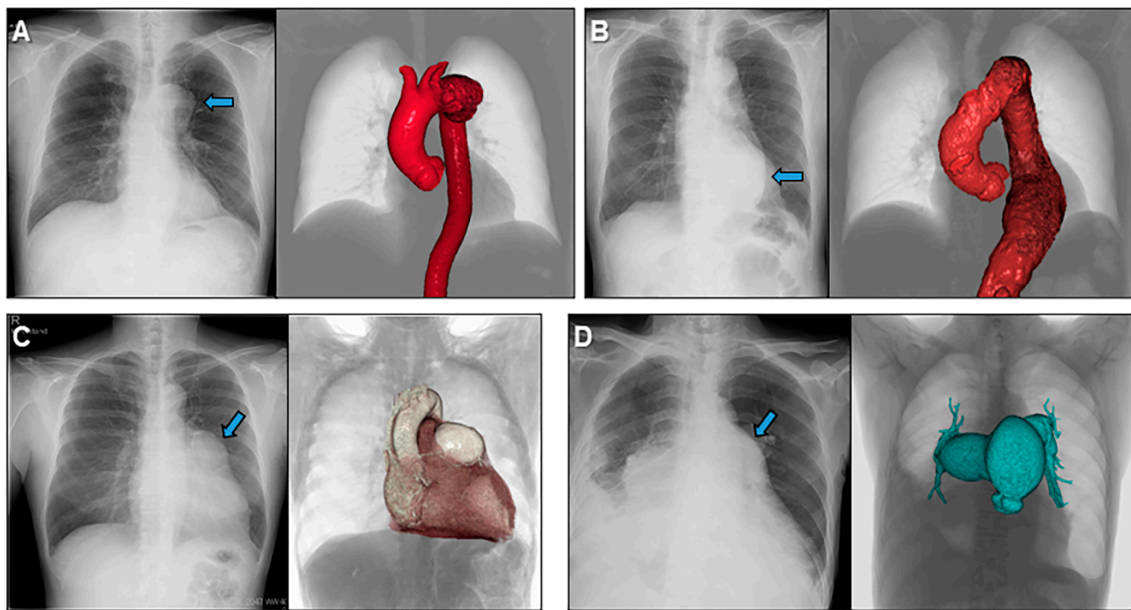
Volume-rendered images to understand abnormal chest radiographies showing a case with aneurysms of the aortic arch (A), descending aorta (B), left coronary artery (C), and pulmonary trunk and pulmonary arteries (D).
